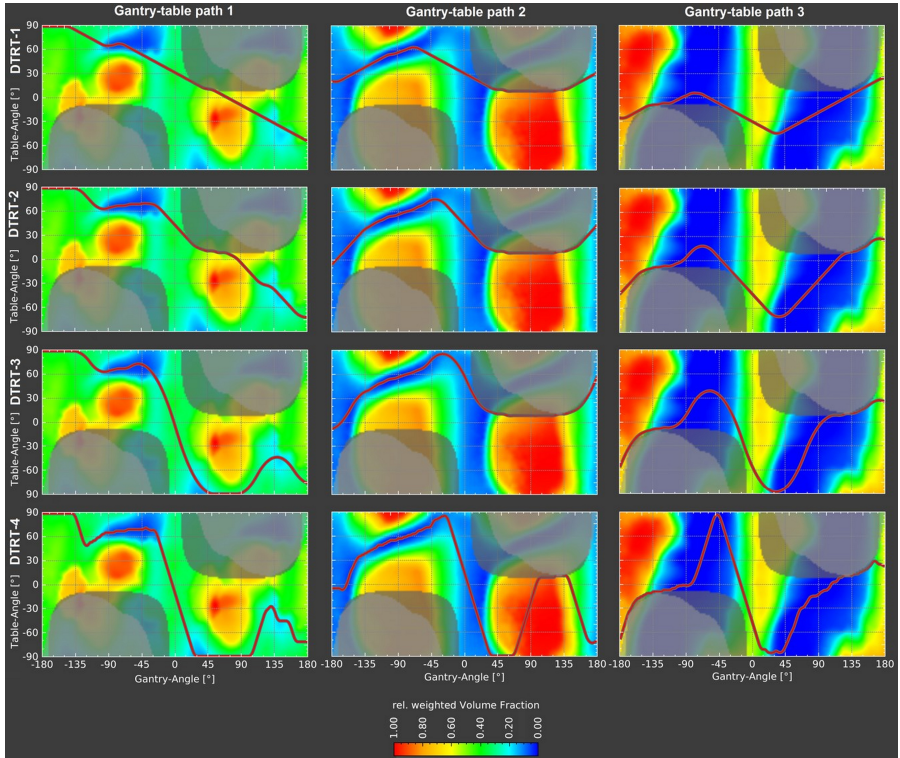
Target-OAR overlap maps with respective DTRT-1 to DTRT-4 paths for case A. With increasing freedom in the GT rotation gradient, the cost for one path is minimized more. In light grey collision zones (between gantry-patient or GT) and in dark grey CT restriction zones are marked.
